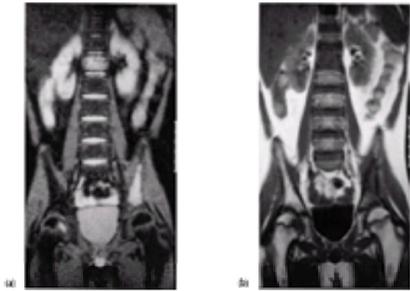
Acute leukaemia relapsing in a 9-year-old boy with normal plain films. (a) Frontal T_1 -weighted MR image. (b) Frontal STIR image. Infiltration of the T12 vertebral body, of the right femoral head, and of left iliac wing.
